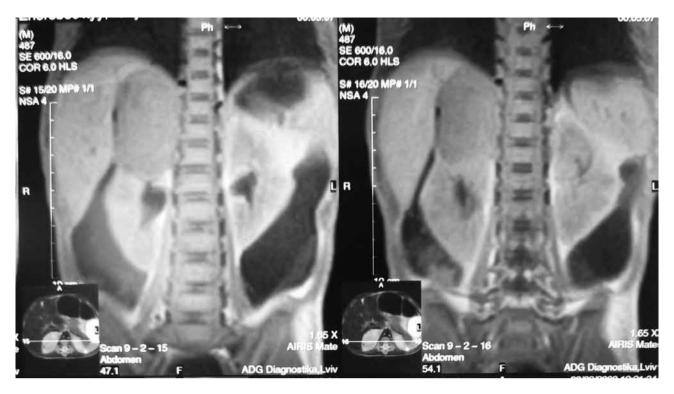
MRI of the patient's abdomen showed a sub-diaphragm paravertebral tumour $63 \times 34 \times 44$ mm, which shrinks down the right kidney and compresses the inferior vena cava
